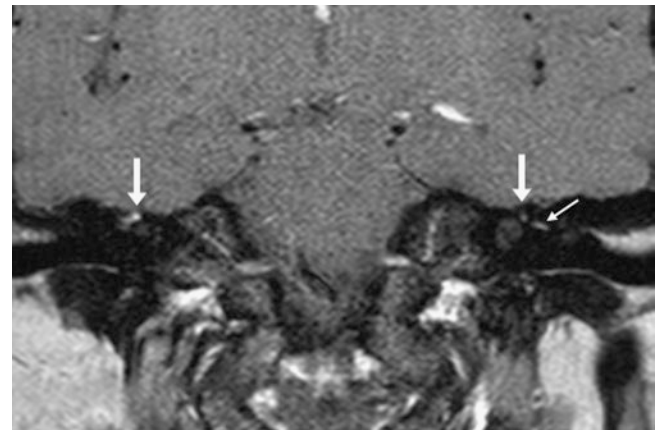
A 60-year-old patient with a negative 1.5 T MRI for tinnitus. A coronal postcontrast FS SET1WI shows asymmetric, mild right geniculate ganglion enhancement (*arrows*) with left horizontal segment enhancement (*thin arrow*)
